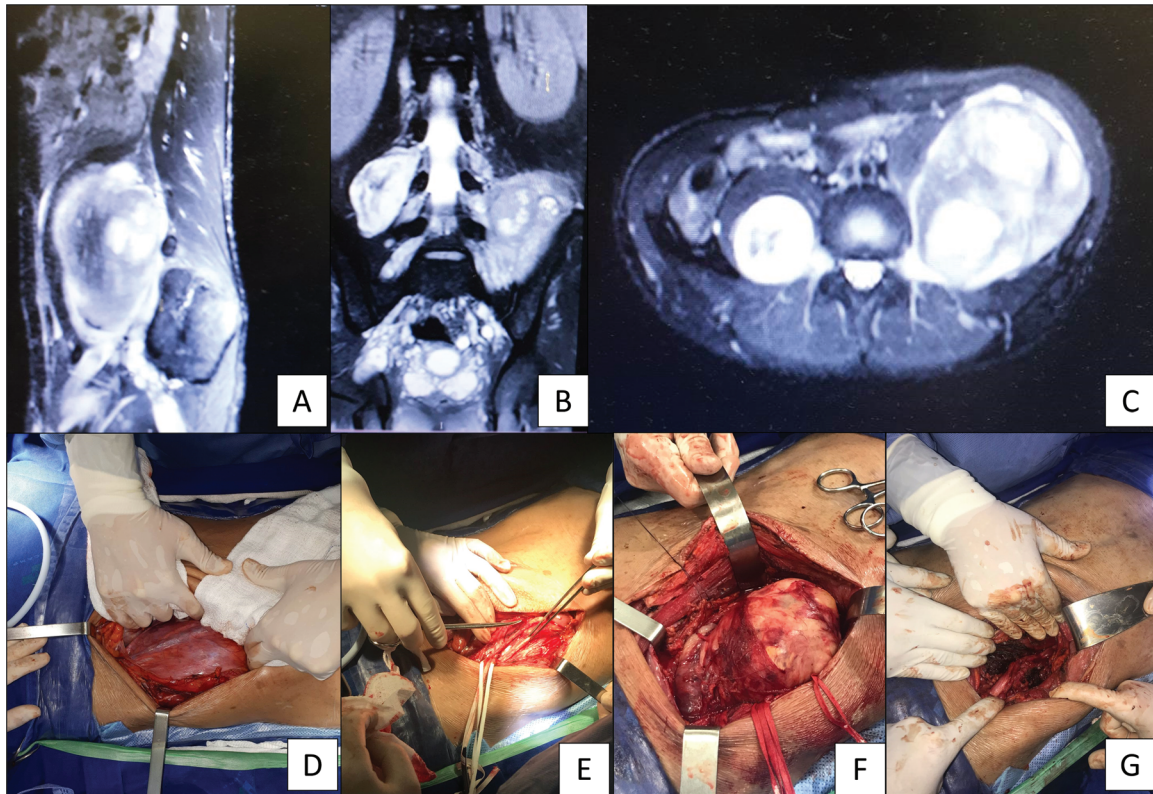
An 18-year-old NF1 patient who complained of an abdominal mass and constipation. He had a giant left retroperitoneal neurofibroma, as shown in the sagittal (A), coronal (B), and axial (C) abdominal CT scans. A left retroperitoneal approach was performed (D), and we identified and isolated the multiple nerves of the lumbar sacral plexus (E) through en bloc resection of the mass (F). Total resection of the malignant peripheral nerve sheath tumor was achieved (G).
